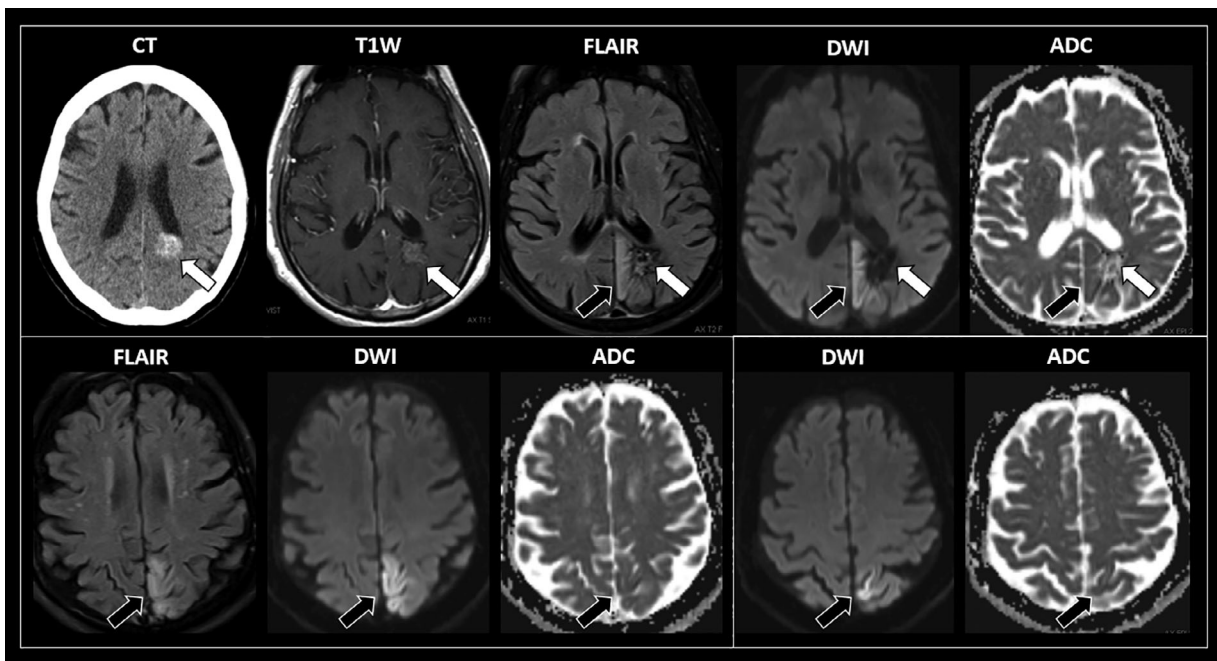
Sequential axial imaging studies of this patient with recurrent abdominal motor seizures. Images inside a white square correspond to the same axial cut. An acute subcortical hemorrhage is evidenced in the left mesial parietal region (white arrows). There is adjacent cortical cytotoxic edema extending cranially through the mesial aspect of the left parietal lobe to reach the postcentral and central sulci near the vertex. This region corresponds to the somatotopic localization of the sensorimotor areas corresponding to the trunk (black arrows). MRI sequences: T1W, T1-weighted MR with intravenous contrast; FLAIR, fluid-attenuated inversion recovery; DWI, diffusion-weighted imaging; ADC, apparent diffusion coefficient.
